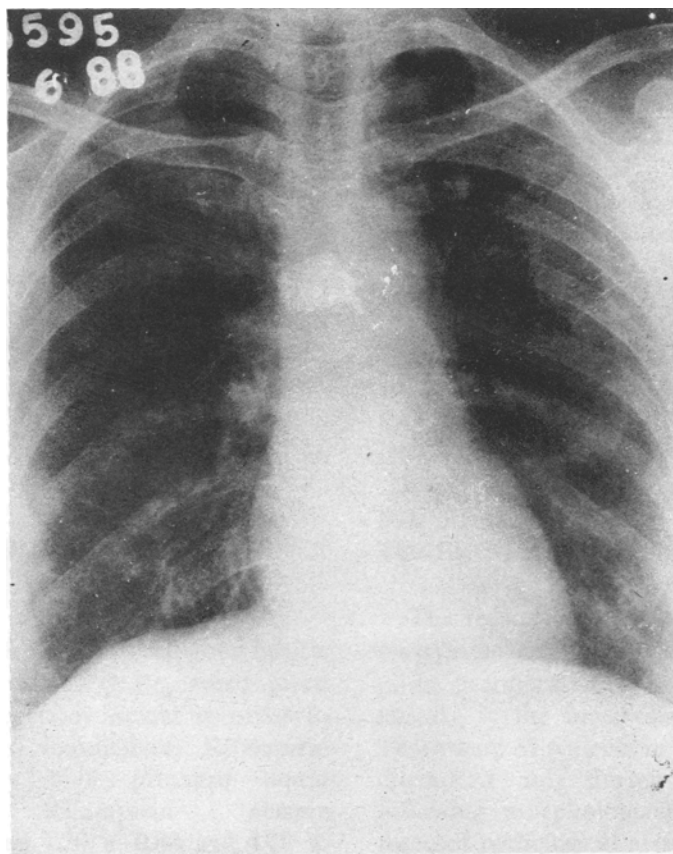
Plain X-ray Chest PA view after Treatment.
